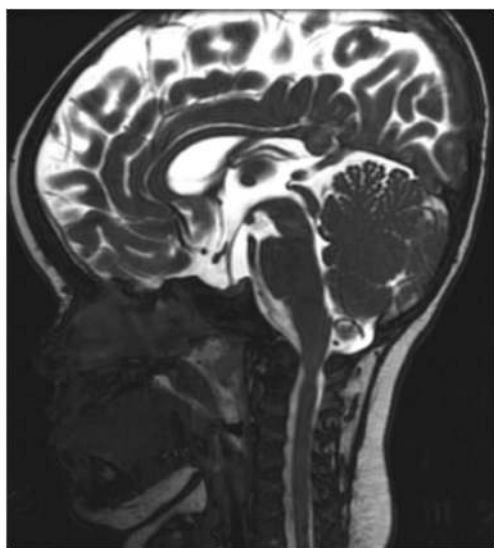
T-2 weighted sagittal image of a patient with achondroplasia demonstrating abundant subarachnoid fluid, the macrocrania of communicating hydrocephalus, and the “shelf” at the foramen magnum resulting from premature closure of the posterior synchondroses and hypertrophied posterior margin of the foramen magnum at the craniovertebral junction. The radiographic and neuroimages are courtesy of Dr. Mai-Lan Ho MD, Associate Professor of Radiology/Neuroradiology, Nationwide Children’s Hospital, Ohio State University College of Medicine, Columbus Ohio
